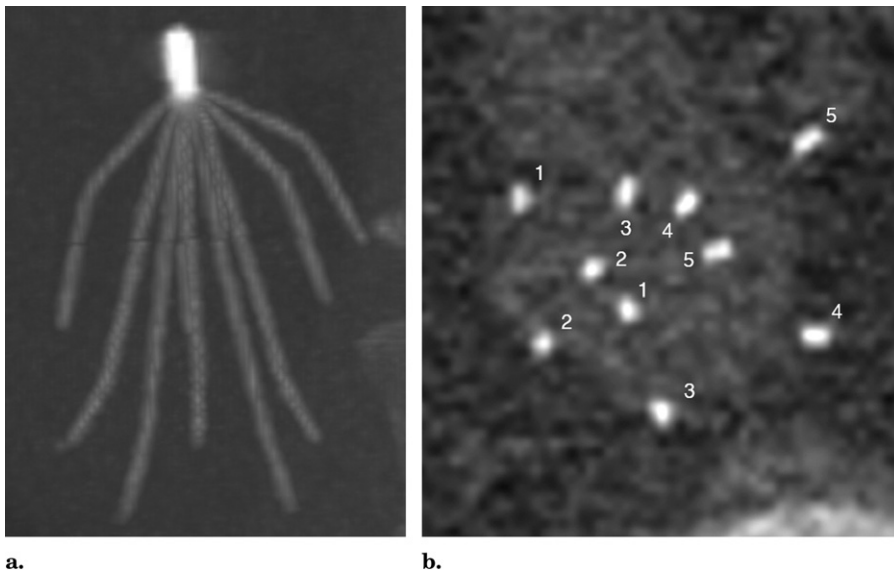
CT scan shows missing alignment strut and anchor strut in Recovery filter. The maximum intensity projection image of the filter (a) shows only five long anchor struts. Cross-sectional imaging through the struts (b) shows only five peripheral anchor struts and five central alignment struts. Two of the peripheral anchor struts (#4 and #5) are shown penetrating the IVC wall. Closer to the filter base, anchor strut #1 also penetrated the IVC wall.
